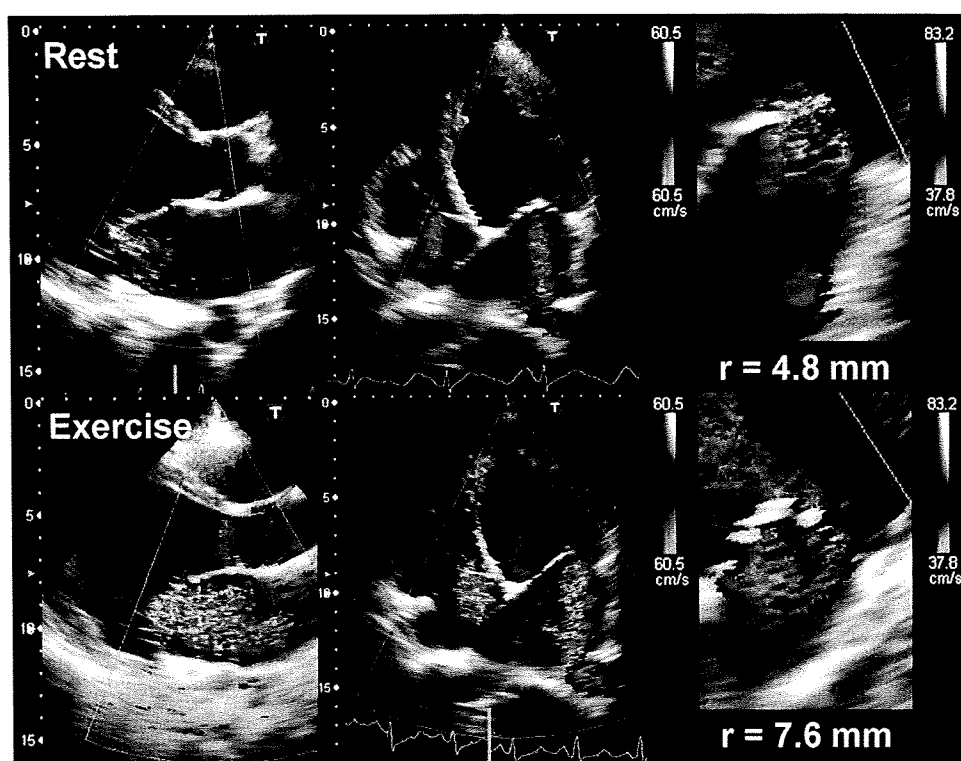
Color Doppler echocardiograms of a patient who showed a large increase in functional MR during exercise. These images reveal an obvious increase in MR by exercise. The radius of the proximal isovelocity surface area (*r*) was increased from 4.8 to 7.6 mm (right) and the ERO from 14.2 to 29.1 mm<sup>2</sup>.
